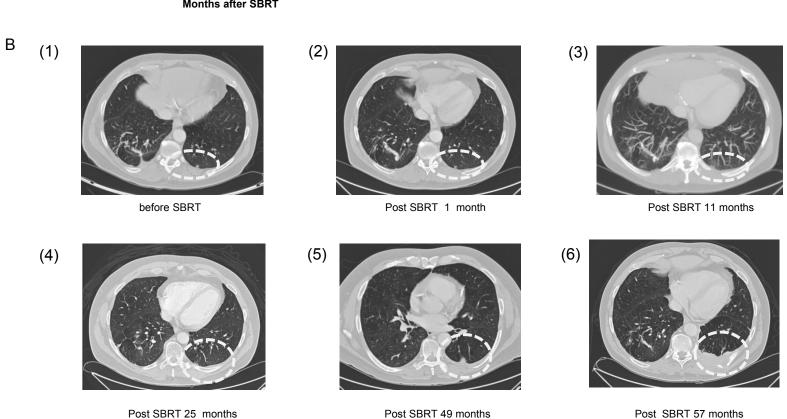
Progression-free/equilibrium diseases are prevailing in cancer patients with ablative SBRT treatment. (A) Percentage of tumor progression over time from patients who have 1-2 oligometastatic lesions. Number of patients: 42; Number of lesions, 53; Lesion sites, see Table S1. (B) CT images of the lung metastatic lesion of a representative patient. CT scans were displayed chronically (1) through (6). The patient had a larynx primary cancer. The lung lesion was treated with three doses of 12Gy and deemed cured by CT scan one year after SBRT (3). Five years later the tumor recurred locally, rapidly grew to invade the chest wall (6). The tumor sites were circled in each scan.
